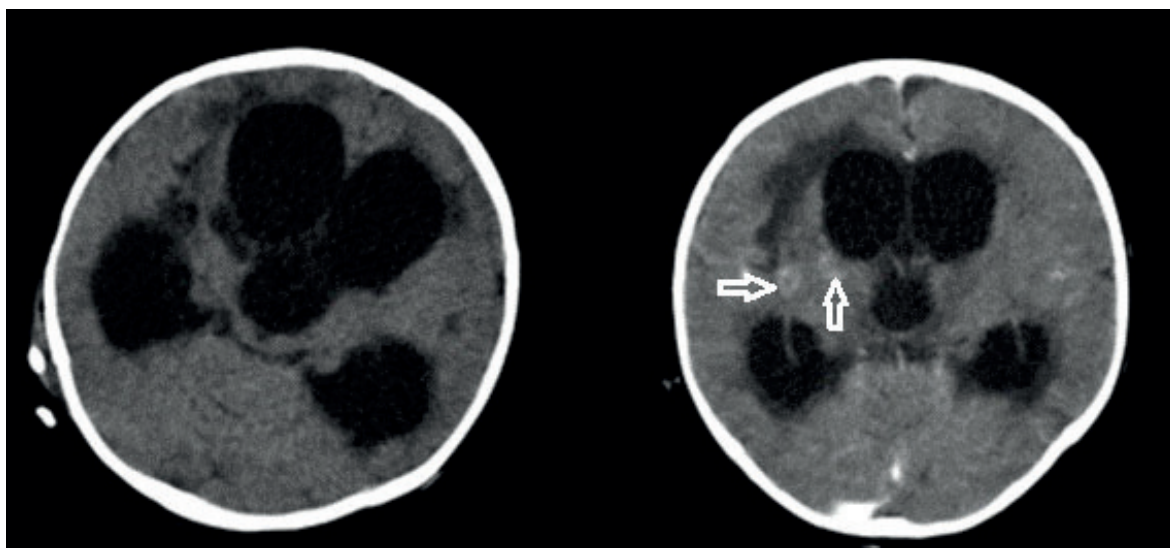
Control cranial computed tomography.
